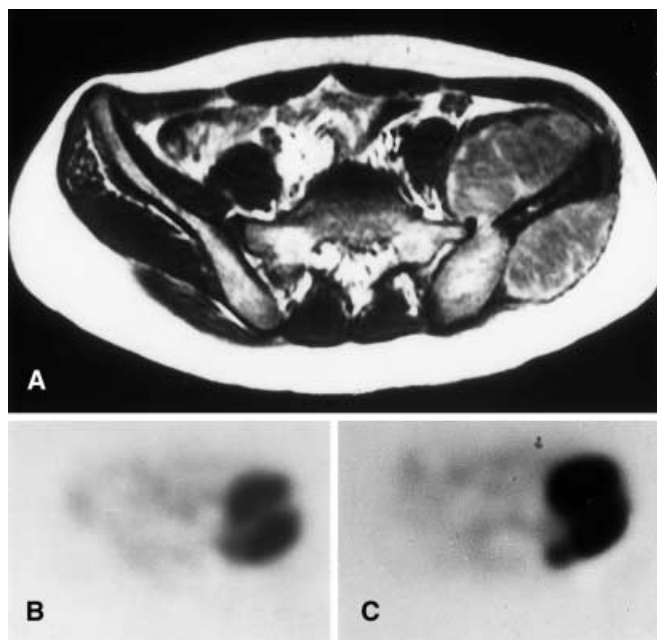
A 12-year-old female (YA) with a high-grade (grade III) Ewing's sarcoma of the left ilium. A T1-weighted MR images (TR/TE = 500/15) with gadolinium enhancement demonstrate destruction of the marrow space and of both anterior and posterior margins of the cortex with extension of huge masses on both sides. PET scan through approximately the same level shows markedly increased FMT (B) and FDG (C) accumulation with SUVs of 3.63 and 8.1, respectively, in a pattern corresponding to the extent of tumour involvement on MRI
